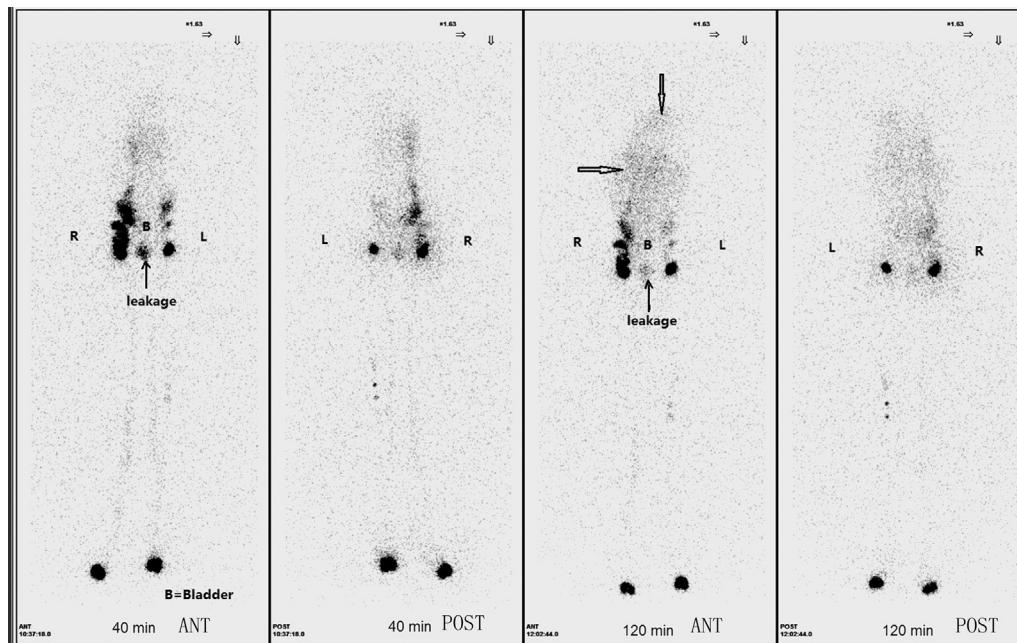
Whole-body lymphoscintigraphy was performed at 40 minutes and 120 minutes after radionuclide injection subcutaneously in the toe webs. Lymphatic leakage was seen in the vagina, which is below the bladder (B). Diffuse radioactivity was seen in the abdomen (arrow), which is correlated with the multiple macrocystic lesions on T2-weighted magnetic resonance imaging (MRI).
